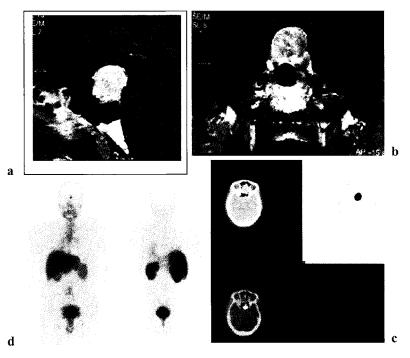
MRI Images of Clinically Non-functional Pituitary Adenoma. Images are contrastenhanced images with Gadolinium (tumor appears white against grey back ground of brain). a Sagittal image, b Coronal image. The same tumor is demonstrated in Figs 4c,d using folate receptor targeted Technetium 99 (FolateScan). c SPECT images with CT scan confirm the uptake within the tumor in the pituitary fossa. d Anterior and posterior whole body planar images showing focal intense radiotracer concentration in the folate-receptor positive pituitary tumor. Tracer distribution was found in the major routes of elimination: kidney, liver, gall bladder and urinary bladder
